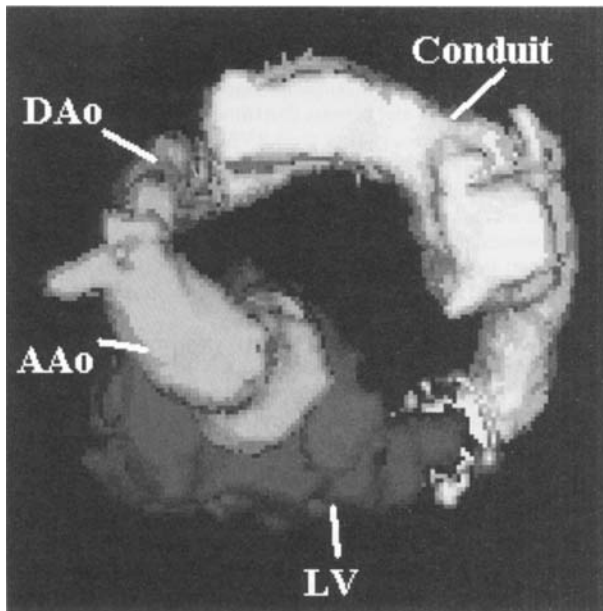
Dimensional MRI of AAC.
